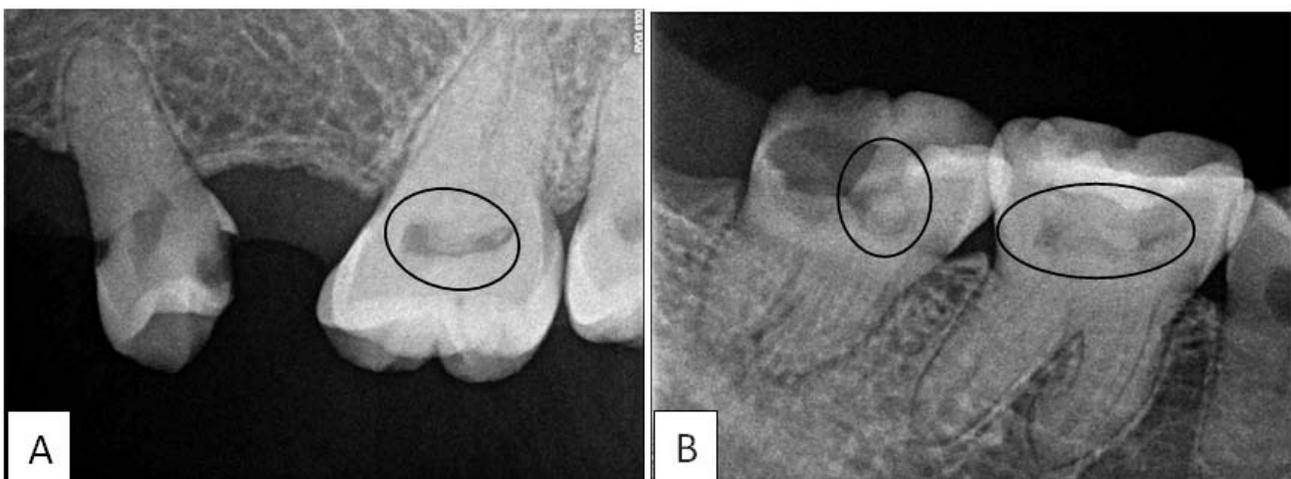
Periapical radiograph of the A) upper left molars and B) lower right molars showing pulp chambers occluded with radiopaque globules and reduction of pulp size
